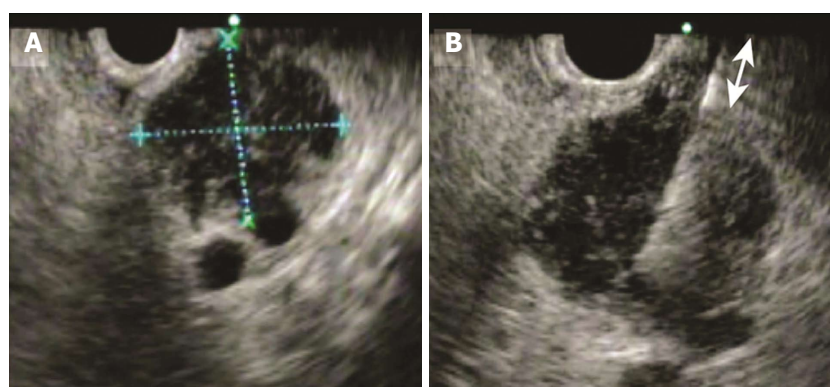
Measurement of tumor diameter and distance to tumor. A: The tumor diameter was measured by endoscopic ultrasonography; B: The distance to the tumor was measured between the upper end of the puncture line and the tumor.
